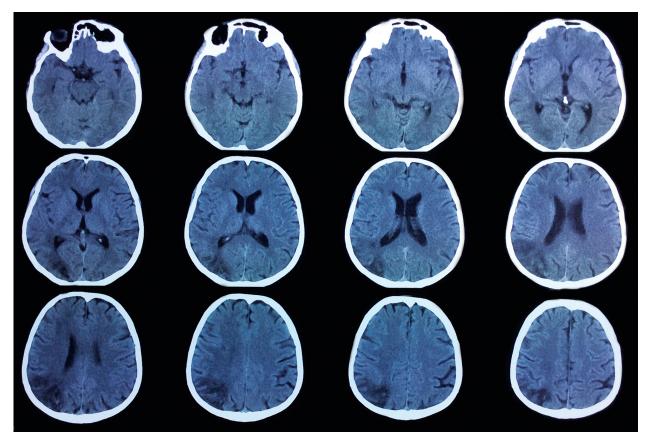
Brain CT scan revealing subacute ischemic strokes in the right MCA–PCA watershed territory and ACA territory, and a right thalamic lacunar infarct. ACA=anterior cerebral artery, CT=computed tomography, MCA=middle cerebral artery, PCA=posterior cerebral artery.
